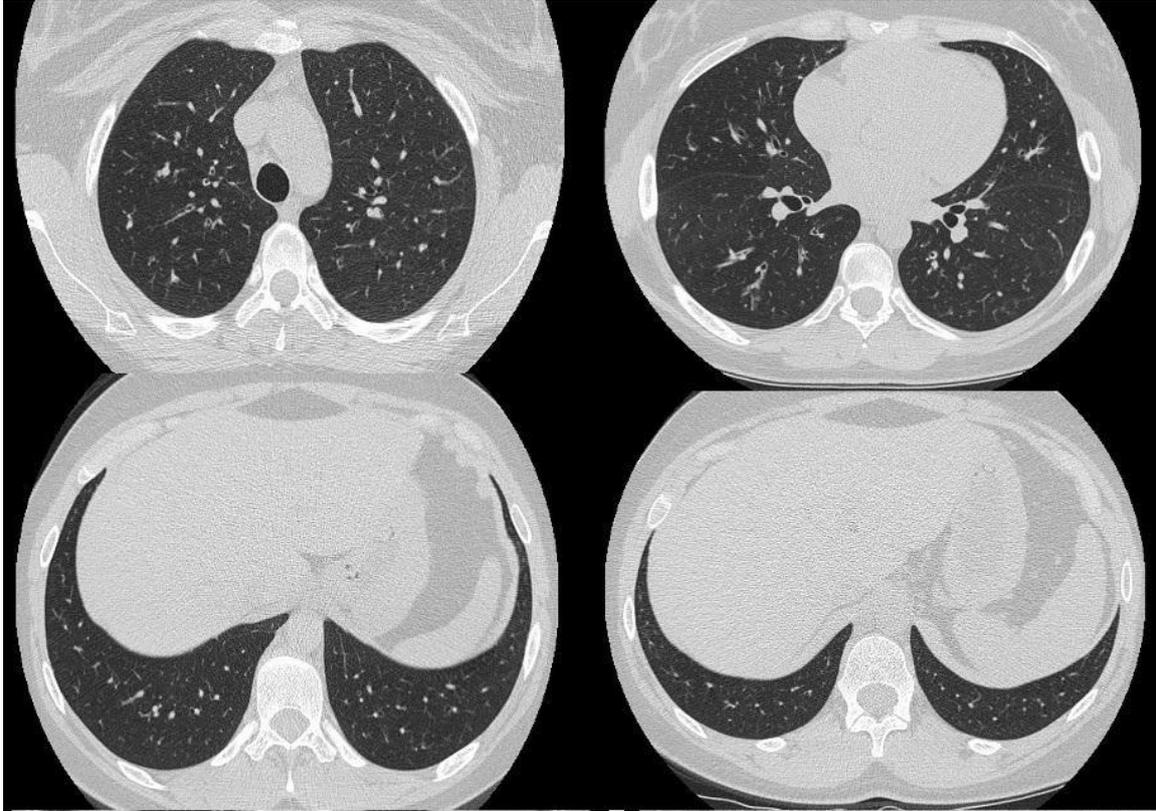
HRCT scan obtained at maximal inspiration shows the typically rounded trachea, well defined pulmonary fissures and bases.
